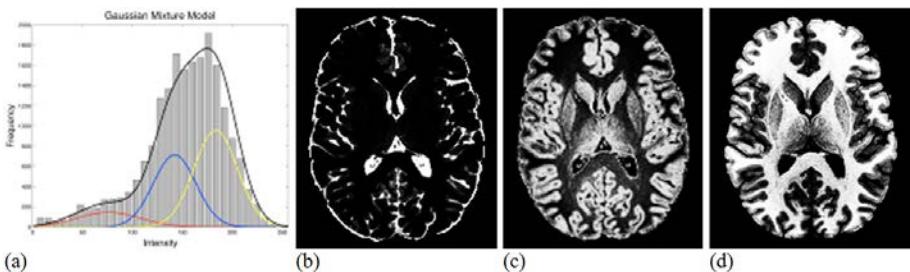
Example of segmentation using Gaussian mixture models. (a) A mixture model fitted to the histogram of the MR image from Fig. 17.19. The mixture model (black curve) is a weighted sum of three Gaussian probability densities, one for each tissue type (red, blue and yellow curves). (b)–(d) CSF, grey matter and white matter probability maps generated by the method. One advantage of Gaussian mixture modelling is that it produces a probabilistic segmentation, rather than a binary segmentation.
